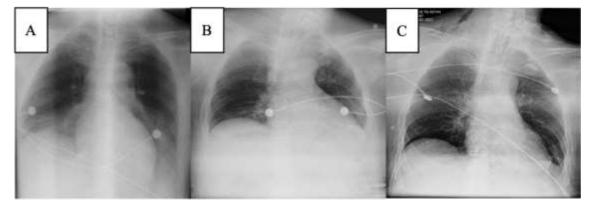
Chest X-ray upon admission showed ground glass opacities in the lower lobes of both lungs, typical of COVID-19 pneumonia (A). Chest X-ray post PDT on the 5th day (B). Chest X-ray on Spontaneous Breathing Trials (SBT) on day 14 of hospitalization showed no progressive infiltrate (C). (source: author's documentation)
